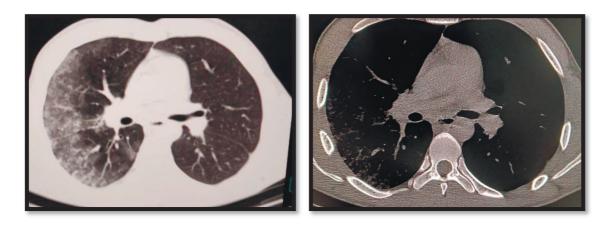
Chest X-ray and MSCT.
